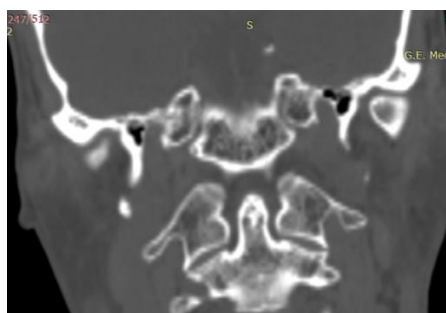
CT scan coronal view of 45years old male with persistent ossiculumterminale.
